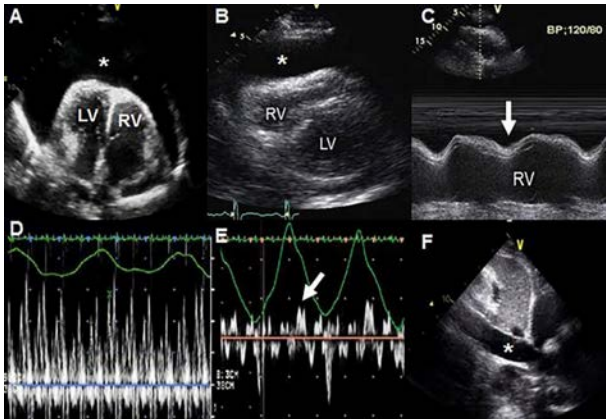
Cardiac tamponade results from impaired ventricular filling: (A) large pericardial fluid accumulation (asterisk) seen in an apical four chamber view; (B) pericardial fluid accumulation (asterisk) shown in a parasternal short axis view between the free wall of the right ventricle and the parietal pericardium; (C) M mode echocardiography shows diastolic collapse of the free wall of the right ventricle; (D) transmitral Doppler flow recording shows a marked decrease in flow velocity with inspiration; (E) Doppler recording shows reversal of flow in the inferior vena cava; (F) inferior vena cava (asterisk) is distended and shows no collapse with inspiration.
